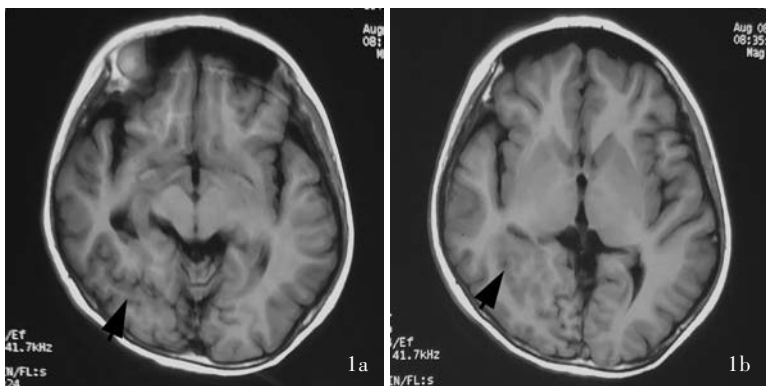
头部 MRI 检查所见 1a 横断面 FLAIR 成像显示,右侧顶枕叶团块状等信号(箭头所示),右侧顶枕叶脑回细小 1b 横断面 FLAIR 成像显示,右侧侧脑室后角旁灰质异位(箭头所示),右侧顶枕叶脑回细小
